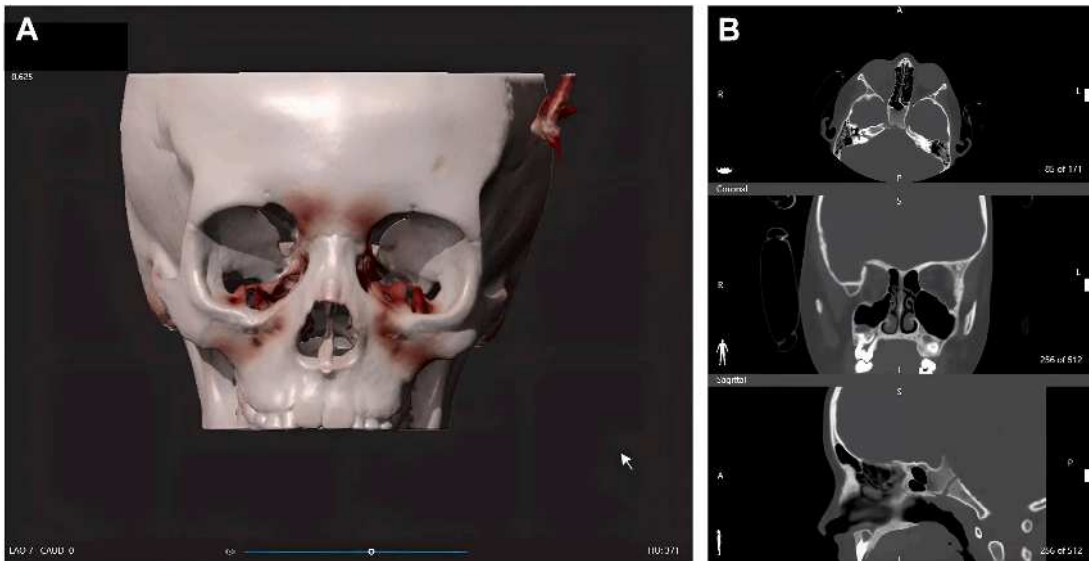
Diagnostic view of CT data of a patient. (A) The 3D volume rendered image and (B) multiplanar view with axial, coronal, and sagittal windows.
